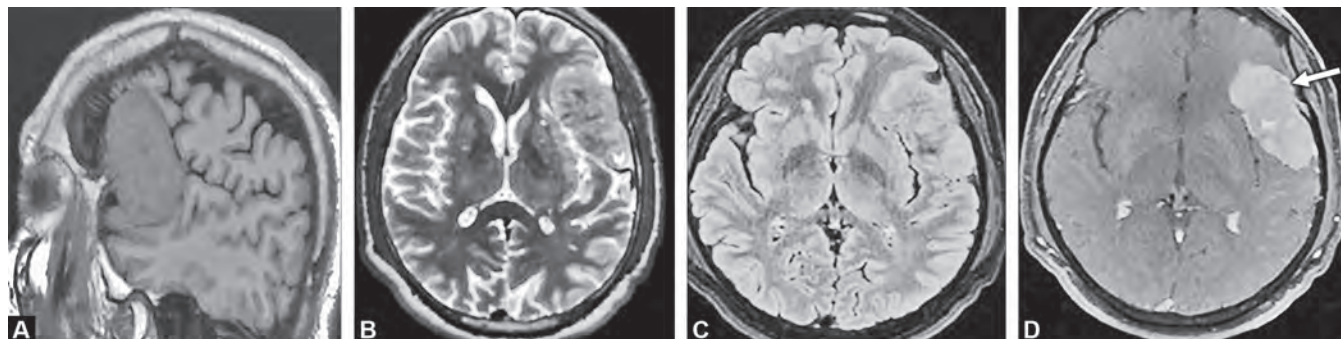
(A) Sagittal T1 W image shows a well-defined lobulated, extra-axial, dural-based lesion predominantly isointense to gray matter seen in the left frontotemporal region with effacement of the adjacent sulci and gyri. (B) On T2 WI and (C) FLAIR, the lesion is isointense to gray matter with CSF cleft sign and displacement of the subarachnoid vessels. The lesion in the (D) post-contrast T1 FS image shows a heterogeneous moderate to intense enhancement
